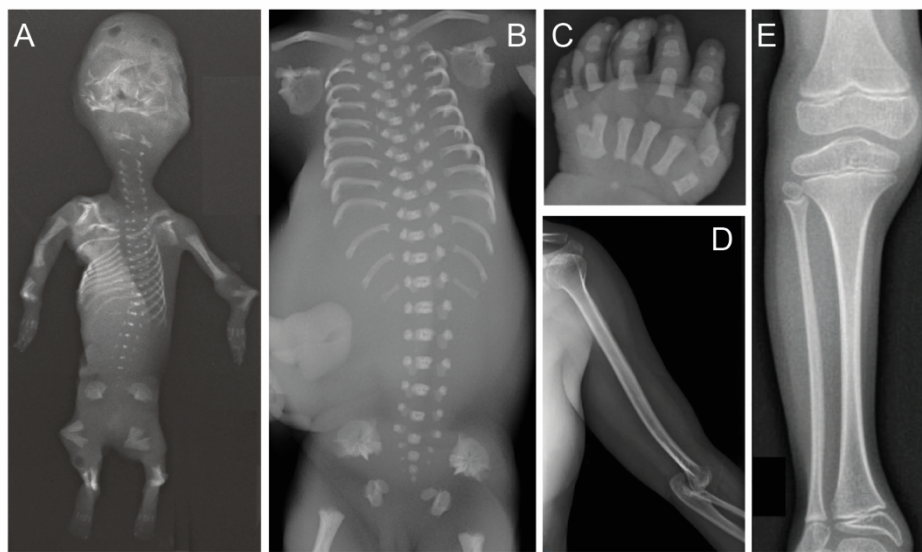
Examples of radiographic signs in patients with skeletal dysplasias. A. Fetus at GA 15 weeks (missed abortion) with kyphomelic dysplasia, poor bone mineralization, deformed skull, trunk, and short angulated bones. B. Fetus with short-rib thoracic dysplasia at 21 weeks GA (termination of pregnancy) with short ribs, short iliac bones, and trident pelvis. C. Hand shows brachydactyly and postaxial polydactyly. D. Radiographs of upper arm of an adult patient with De Hauwere syndrome, note gracile humerus, and elbow dislocation. E. Lower extremity radiograph of a 5-year-old child with Saul-Wilson syndrome with slender tubular bones with metaphyseal flaring and large epiphyses. GA, gestational age.
